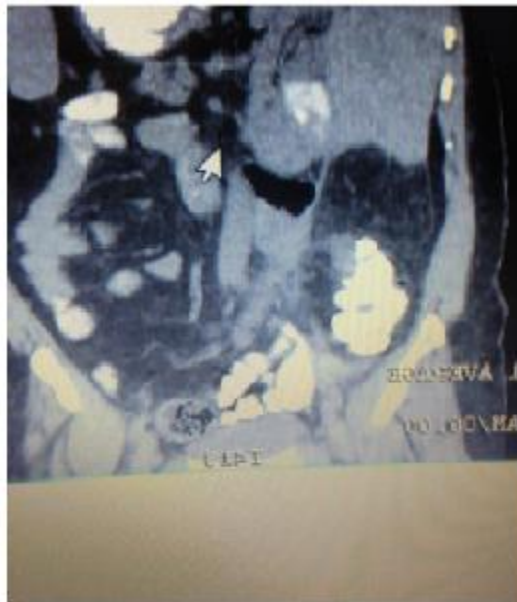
CT suggests perforated DD (arrowhead) with free air in the retroperitoneum
